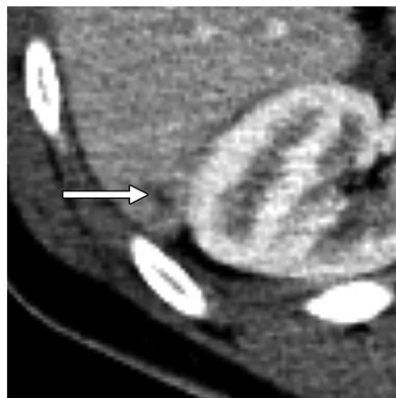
Incidental adrenal pathologic finding at trauma imaging with dual bolus CT. (a) Axial CT image shows a right adrenal lesion (arrow) with a 40-HU attenuation value, which was initially considered to be an incidental indeterminate adrenal nodule. In the context of trauma, an apparent incidental adrenal lesion may represent adrenal hemorrhage. (b–d) Axial CT images (b, c) show, at closer evaluation, haziness of the periadrenal fat (arrow in b) and a small associated liver laceration (arrow in c). These findings support a diagnosis of adrenal hemorrhage, as does the subsequent resolution (arrow in d) on the axial gradient-echo out-of-phase MR image (d) obtained at follow-up.
